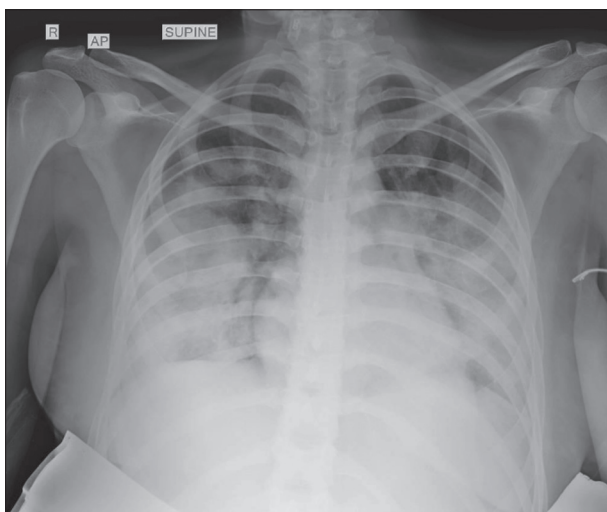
X-ray of the patient's heart and lungs on the eighth day of illness, before the administration of tocilizumab; chest radiograph reveals shadows in bilateral lung fields, with preserved transparency of the lung apices
